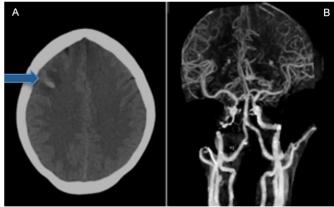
Imaging findings. (A) CT of the head showing right frontal subarachnoid haemorrhage (arrow). (B) CT angiogram of the head showing no evidence of an aneurysm.
